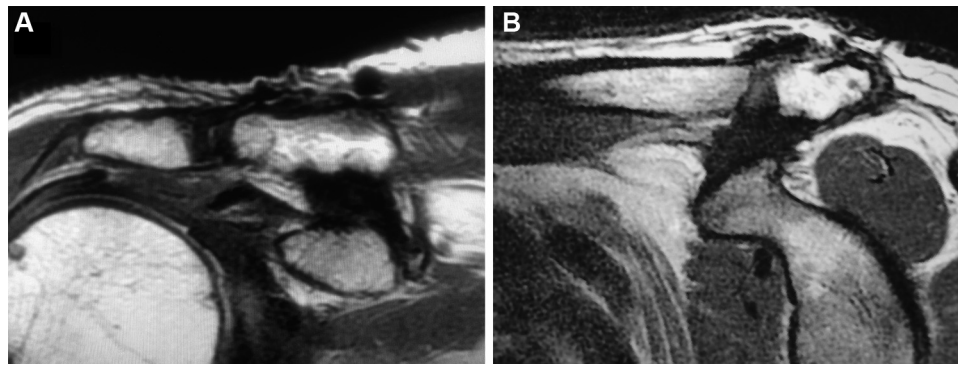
Coronal magnetic resonance images of 2 patients showing the coracoclavicular interval at (A) 2 years and (B) 4 years postoperatively. Note the increase in width and density of the soft tissue complex within the coracoclavicular interval with time.
